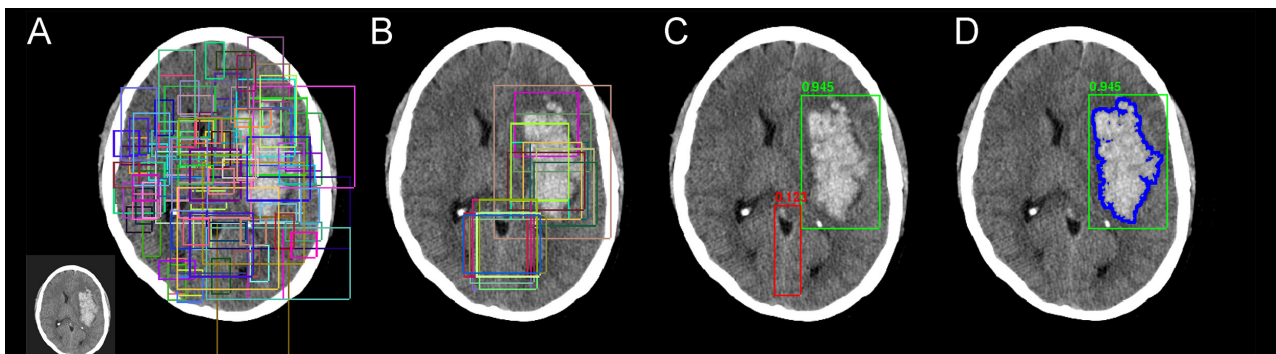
Two-step AI process for hemorrhage detection on CT that first glanced at a given image (A) to identify potential areas of abnormality (B) and then individually attended to each suspicious region (C) before making a final diagnosis (D).
